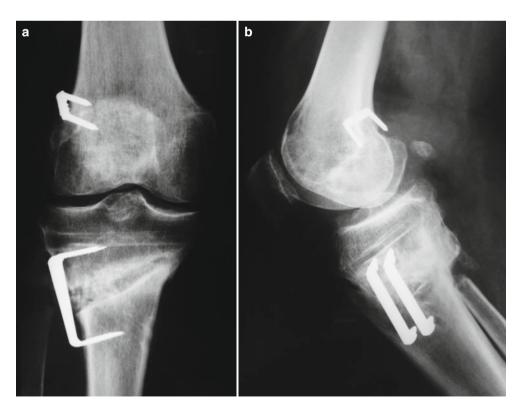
(a, b) Postoperative X-rays
